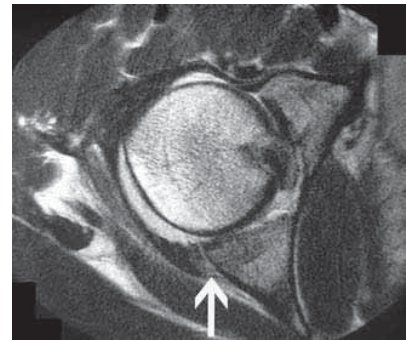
An axial T1-weighted MRI scan showing posterior hip subluxation and a nondisplaced posterior acetabular fracture (*arrow*), an anterior labral tear, and disruption of the iliofemoral ligament with a hemarthrosis.
